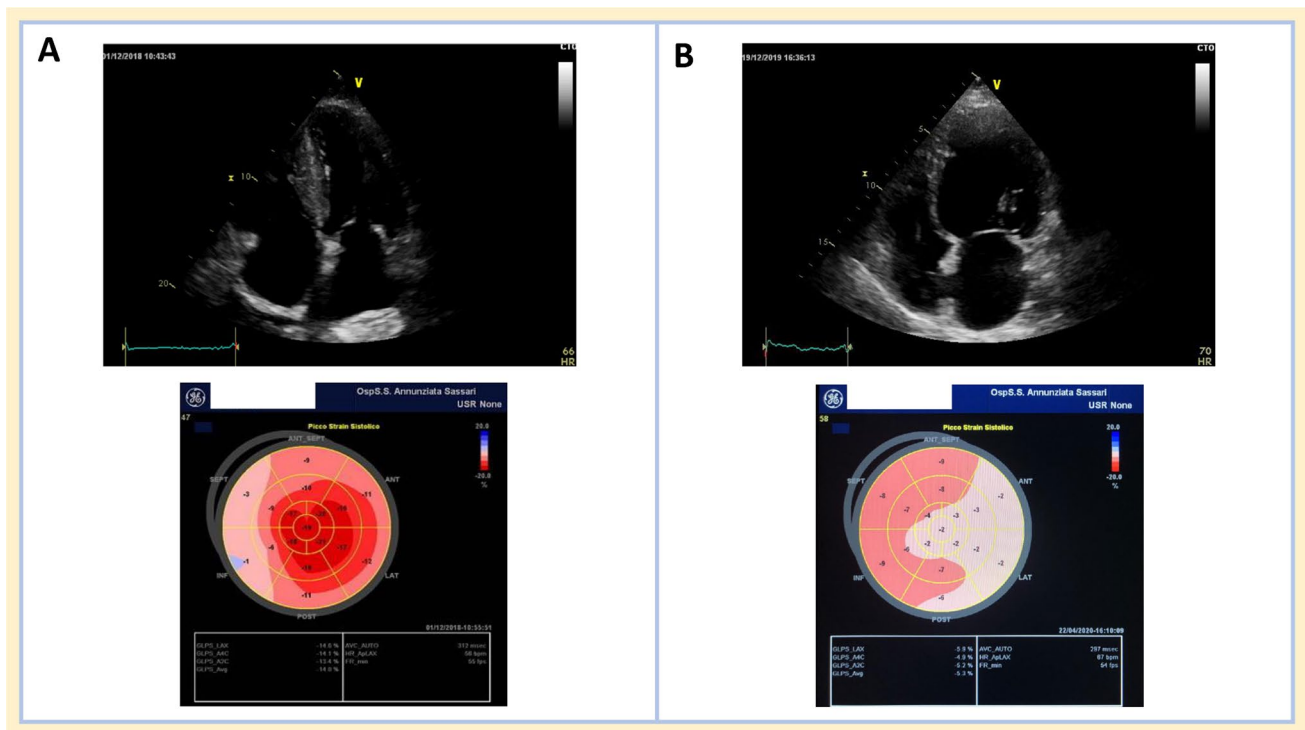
Two *real-world* clinical examples (Heart Failure Clinic, Sassari University Hospital) showing the pros and cons of the use of GLS in HF. Left panel (pros) A: a 75-year-old man with clinical and laboratory features suggesting amyloidosis. Abdominal fat pad biopsy negative. Thanks to the detection of typical echocardiographic features (i.e., “apical sparing”), the diagnosis was not ruled out and the patient underwent further tests confirming it. Right panel (cons) B:
